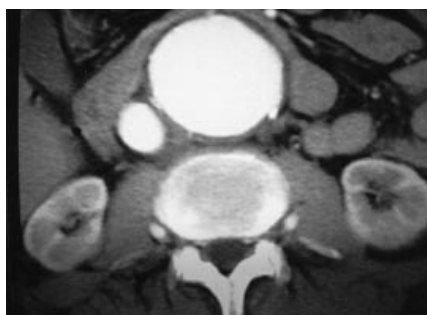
Contrast-enhanced computed tomography demonstrates abnormal early enhancement of the inferior vena cava during the arterial-dominant phase of the examination adjacent to an infra-renal abdominal aortic aneurysm.
